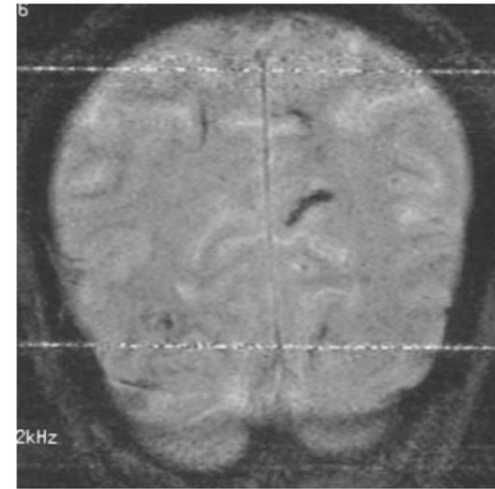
64-year-old man. Coronal gradient-echo MR image (640/25/2) shows linear hypointense subcortical lesions, which might represent hemorrhagic tracks.
